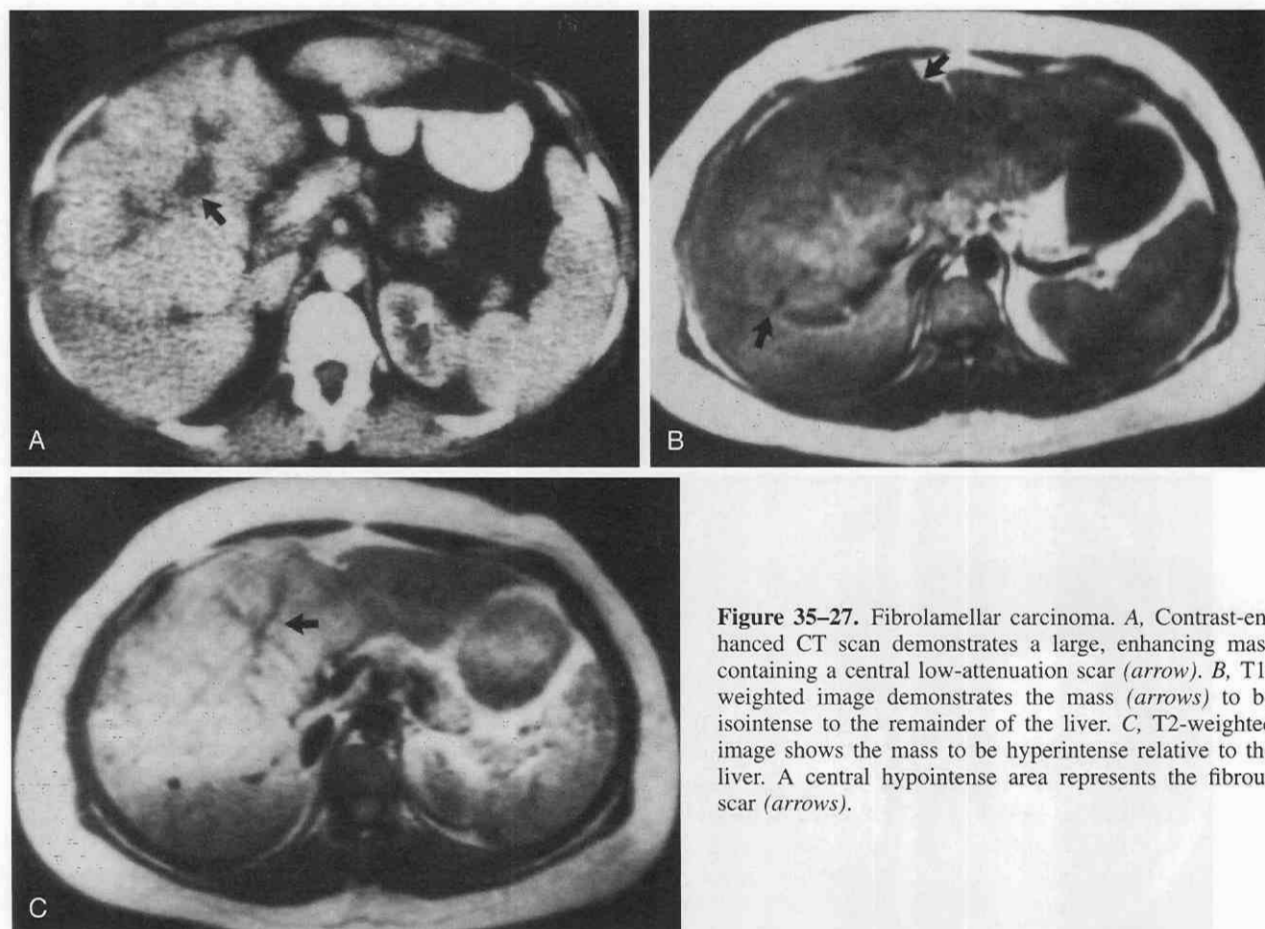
Fibrolamellar carcinoma. A, Contrast-enhanced CT scan demonstrates a large, enhancing mass containing a central low-attenuation scar (arrow). B, T1-weighted image demonstrates the mass (arrows) to be isointense to the remainder of the liver. C, T2-weighted image shows the mass to be hyperintense relative to the liver. A central hypointense area represents the fibrous scar (arrows).
